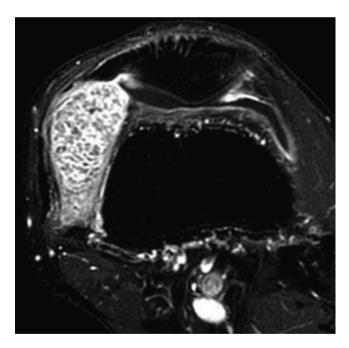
Axial fat-saturated T1-weighted magnetic resonance image post IV gadolinium demonstrates multiple low-signal osteochondral bodies within the enhancing synovium
